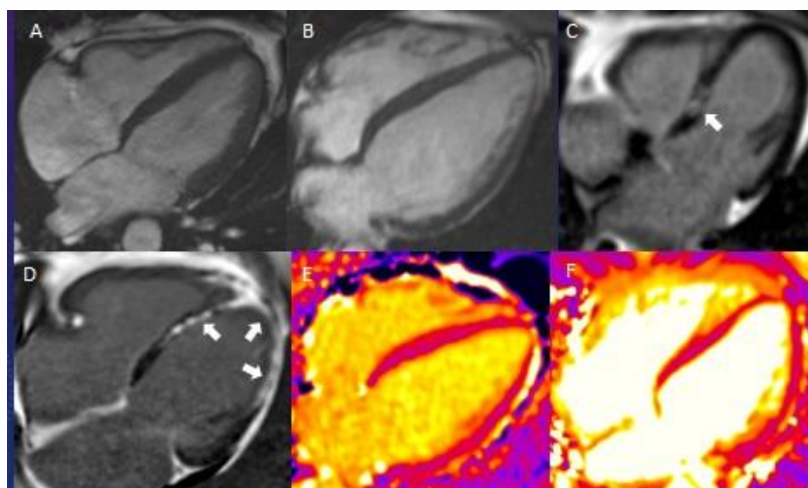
Static Cardiac MRI images demonstrating different pathologies in PLWH: A) Normal Heart B) Dilated Cardiomyopathy with Heart Failure C) Patchy LGE D) Old MI with Scar E) Native T1 Mapping showing increased fibrosis F) T2 Mapping which is normal.
